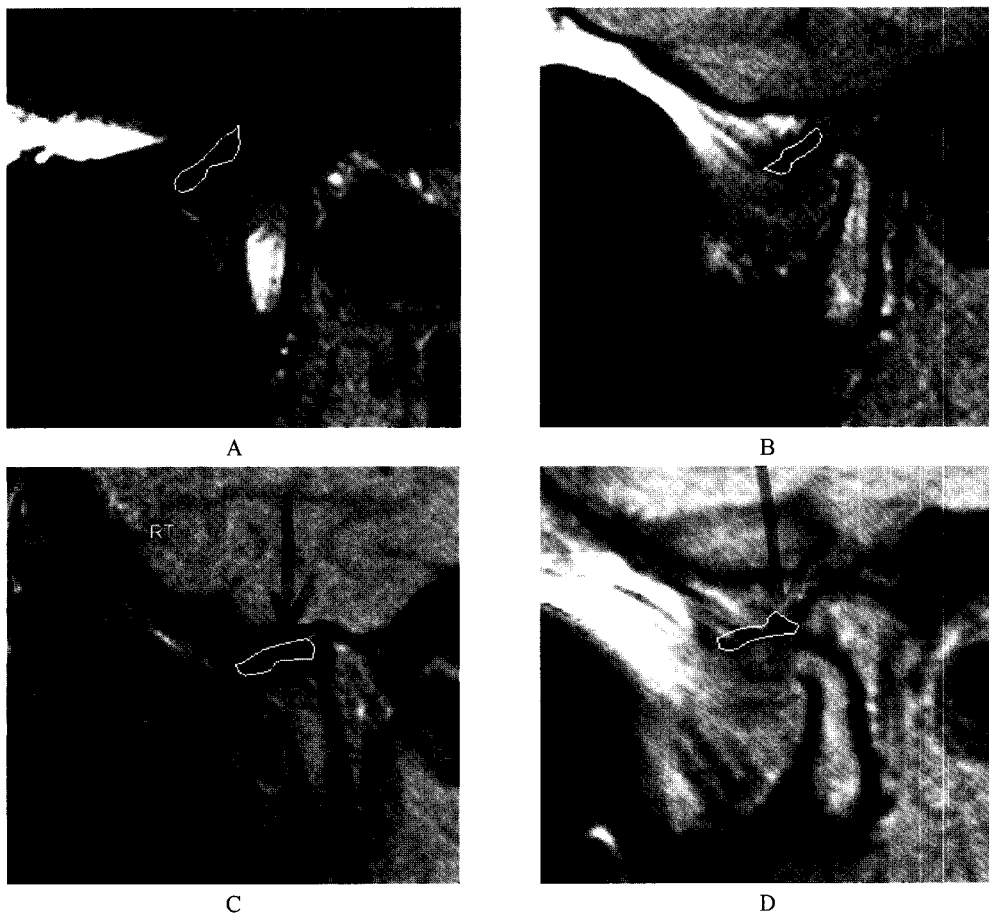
MRI finding of pretreatment in case 2
